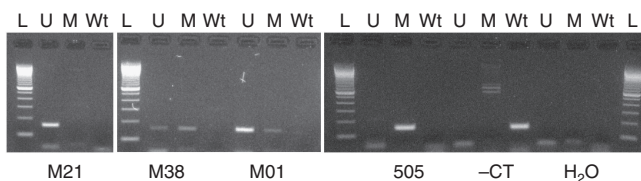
Representative gel images from the methylation-specific PCR (MSP) analyses. L = 100 bp DNA ladder, U/M/Wt = PCR products from the PCR specific for unmethylated, methylated, and non-CT converted-specific MSP reactions, respectively. Samples were M21, M38, and M01, and control reactions for the MSP were the methylation-positive cell line 505, Wt-positive CT-converted control DNA (-CT), and non-template control for PCR (H₂O). CT, bisulfite conversion of cytosine to thymidine.
